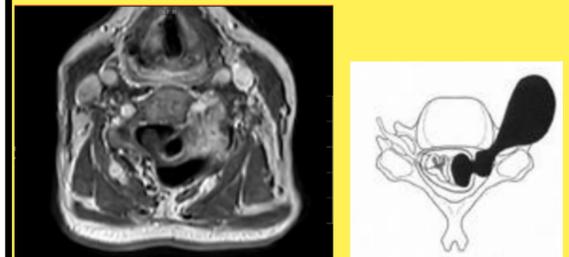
(left) 76/F with history of C5/6 schwannoma and laminectomy done 23 years ago, had an increased left limb numbness & weakness. MRI showed a Toyama Class IIB tumor of size 39 x 25mm x 32mm compressing left VA V2 segment anteriorly with significant narrowing. Expanded left transverse foramen and eroded left pedicle with sclerotic margin at C5-6 levels were noted. Left C5/6 facetectomy & tumor excision with PSF was performed. GTR achieved. Intra-op blood loss 120ml, no immediate post-op complication
